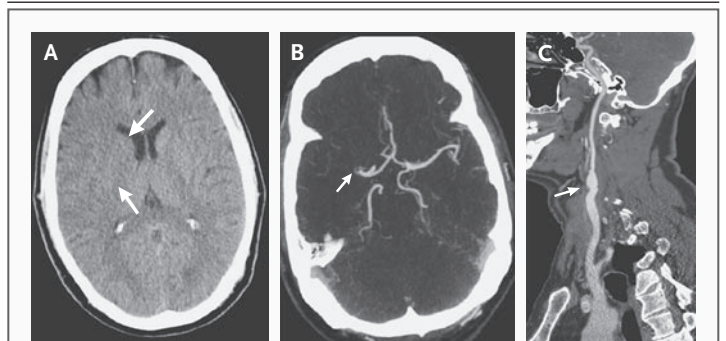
CT Scans Obtained 1 Hour 40 Minutes after the Onset of Symptoms Suggestive of Cortical Stroke in the Territory of the Right Middle Cerebral Artery.
